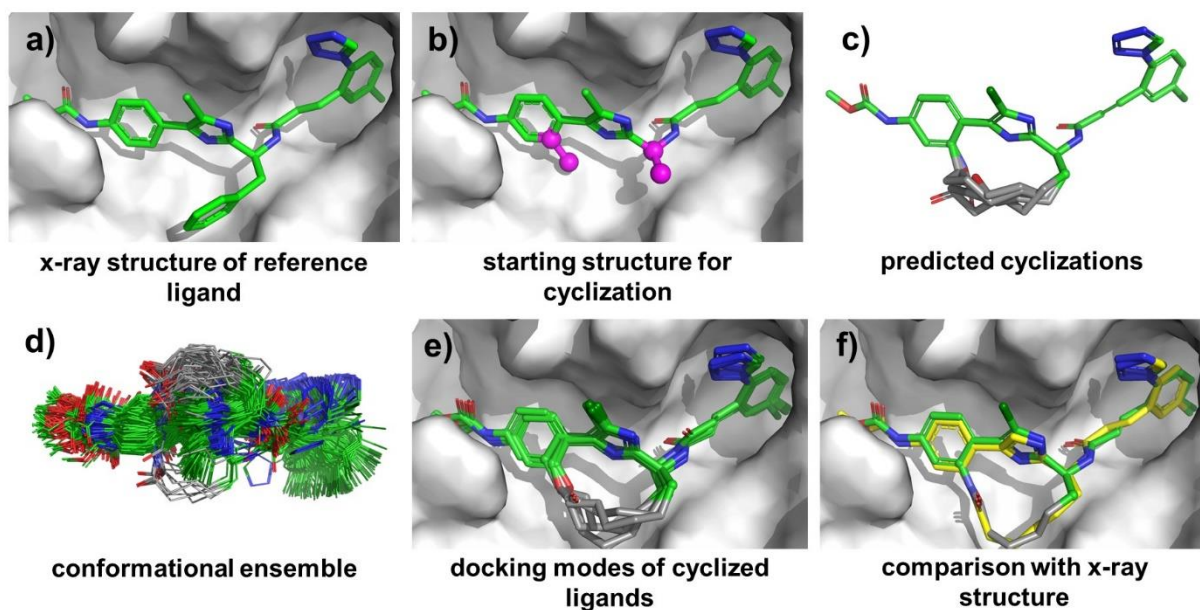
Macrocyclization of a factor XIa inhibitor. a) x-ray structure of acyclic phenyl imidazole lead compound (pdb code 4y8x). b) The lead structure was modified to obtain the starting structure for cyclization. The attachment vectors are indicated in magenta. c) Cyclized conformations of 7a-f obtained after automated attachment of linkers (see Table 7) to the starting structure. d) Conformational ensemble obtained from Prime-MCS (shown for 7e). e) Predicted binding modes of 7a-f obtained from docking with Glide. f) Comparison of predicted binding mode of 7e with the x-ray structure of a close analogue (pdb code 5tku).
